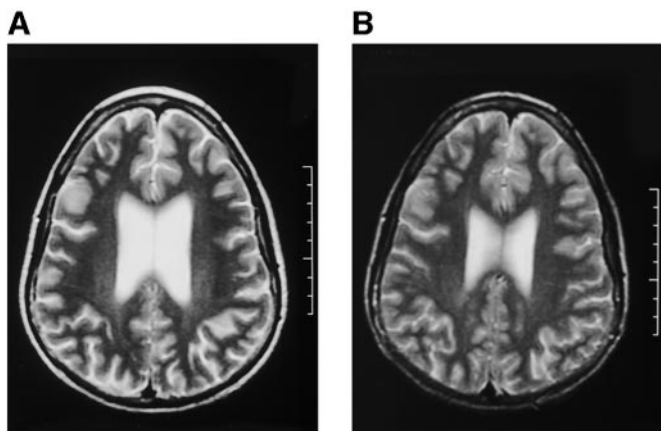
MRI of the brain of a 15-yr-old male with Cushing disease revealed cerebral atrophy and ventricular enlargement (A) which resolved 1 yr after surgery and correction of hypercortisolism (B).
